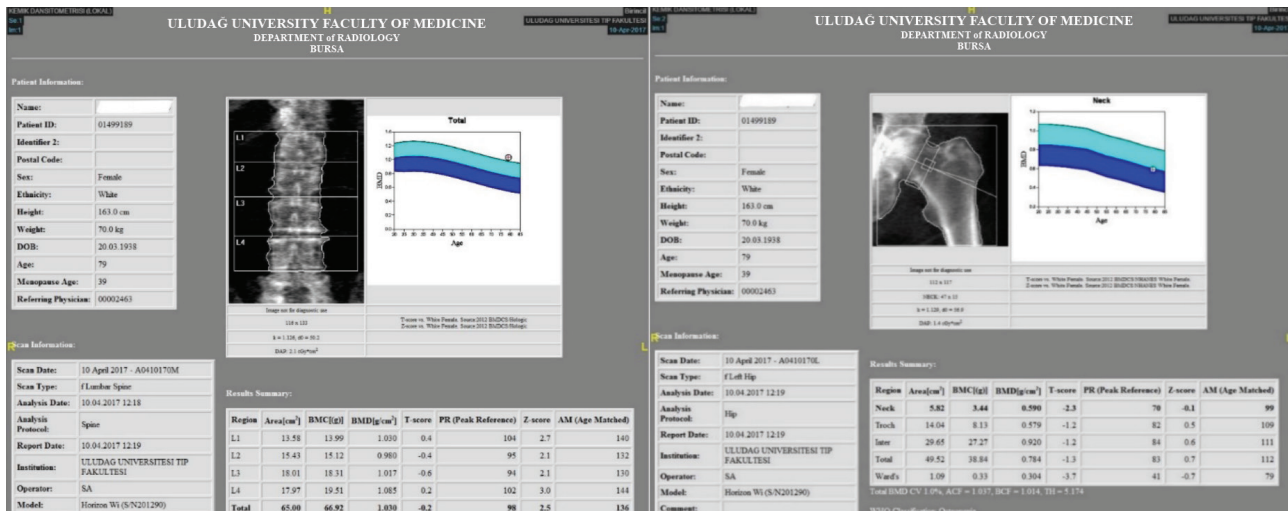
Bone mineral density and T-score measurement by dual-energy X-ray absorptiometry
